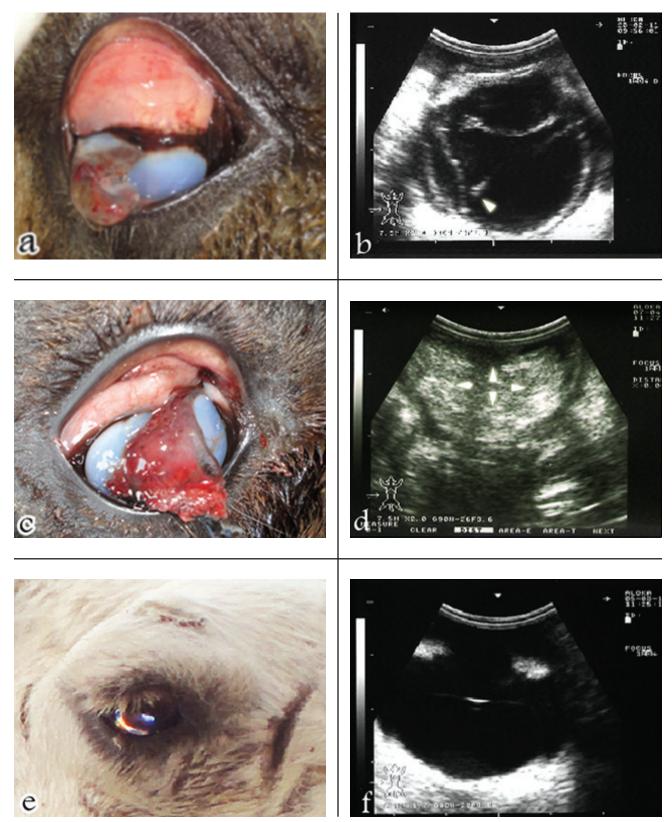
a- Penetrating corneal wound, corneal opacity, with slight vitreous prolapse; b-partial retinal detachment (arrow) and retinal folds are seen within the vitreous body; c- Penetrating corneal wound due to severe trauma with prolapse of blood mixed vitreous material; d- high reflective wide-spread opacities covering the lens (arrows) and occupying the vitreal space corresponding to vitreal haemorrhage; e- Blind eye with dilated irresponsive pupil from which fundal reflection was pictured. Traditional firing lines around the eye are evident; f-clear ocular sonographic image with widely dilated pupil.
